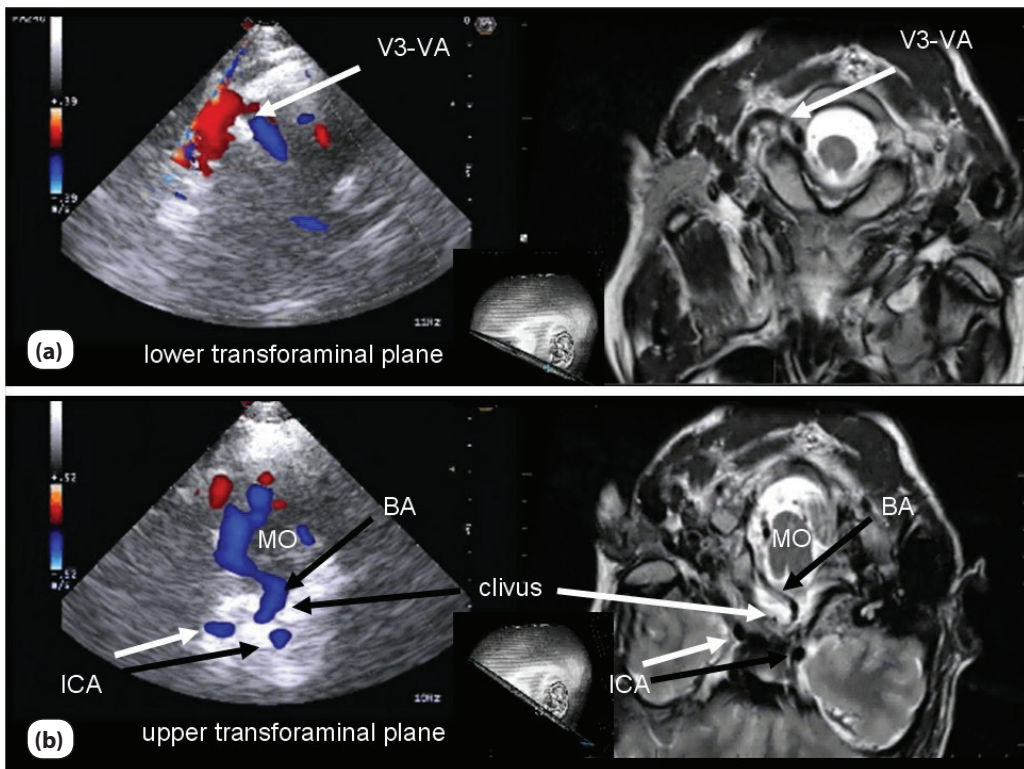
Examples of upper and lower transforaminal planes. Ultrasound fusion image (color-mode) matched with a T2-weighted MRI dataset of a patient without pathological findings (a) visualization of the V3-VA and proximal V4-V-segment. Note the angle of the insonation plane aiming for the nasion of the subject; (b) visualization of an elongated basilar artery (BA). Note, that the two blue-coded signals distal to the BA are derived from the ICA and not the PCA.
